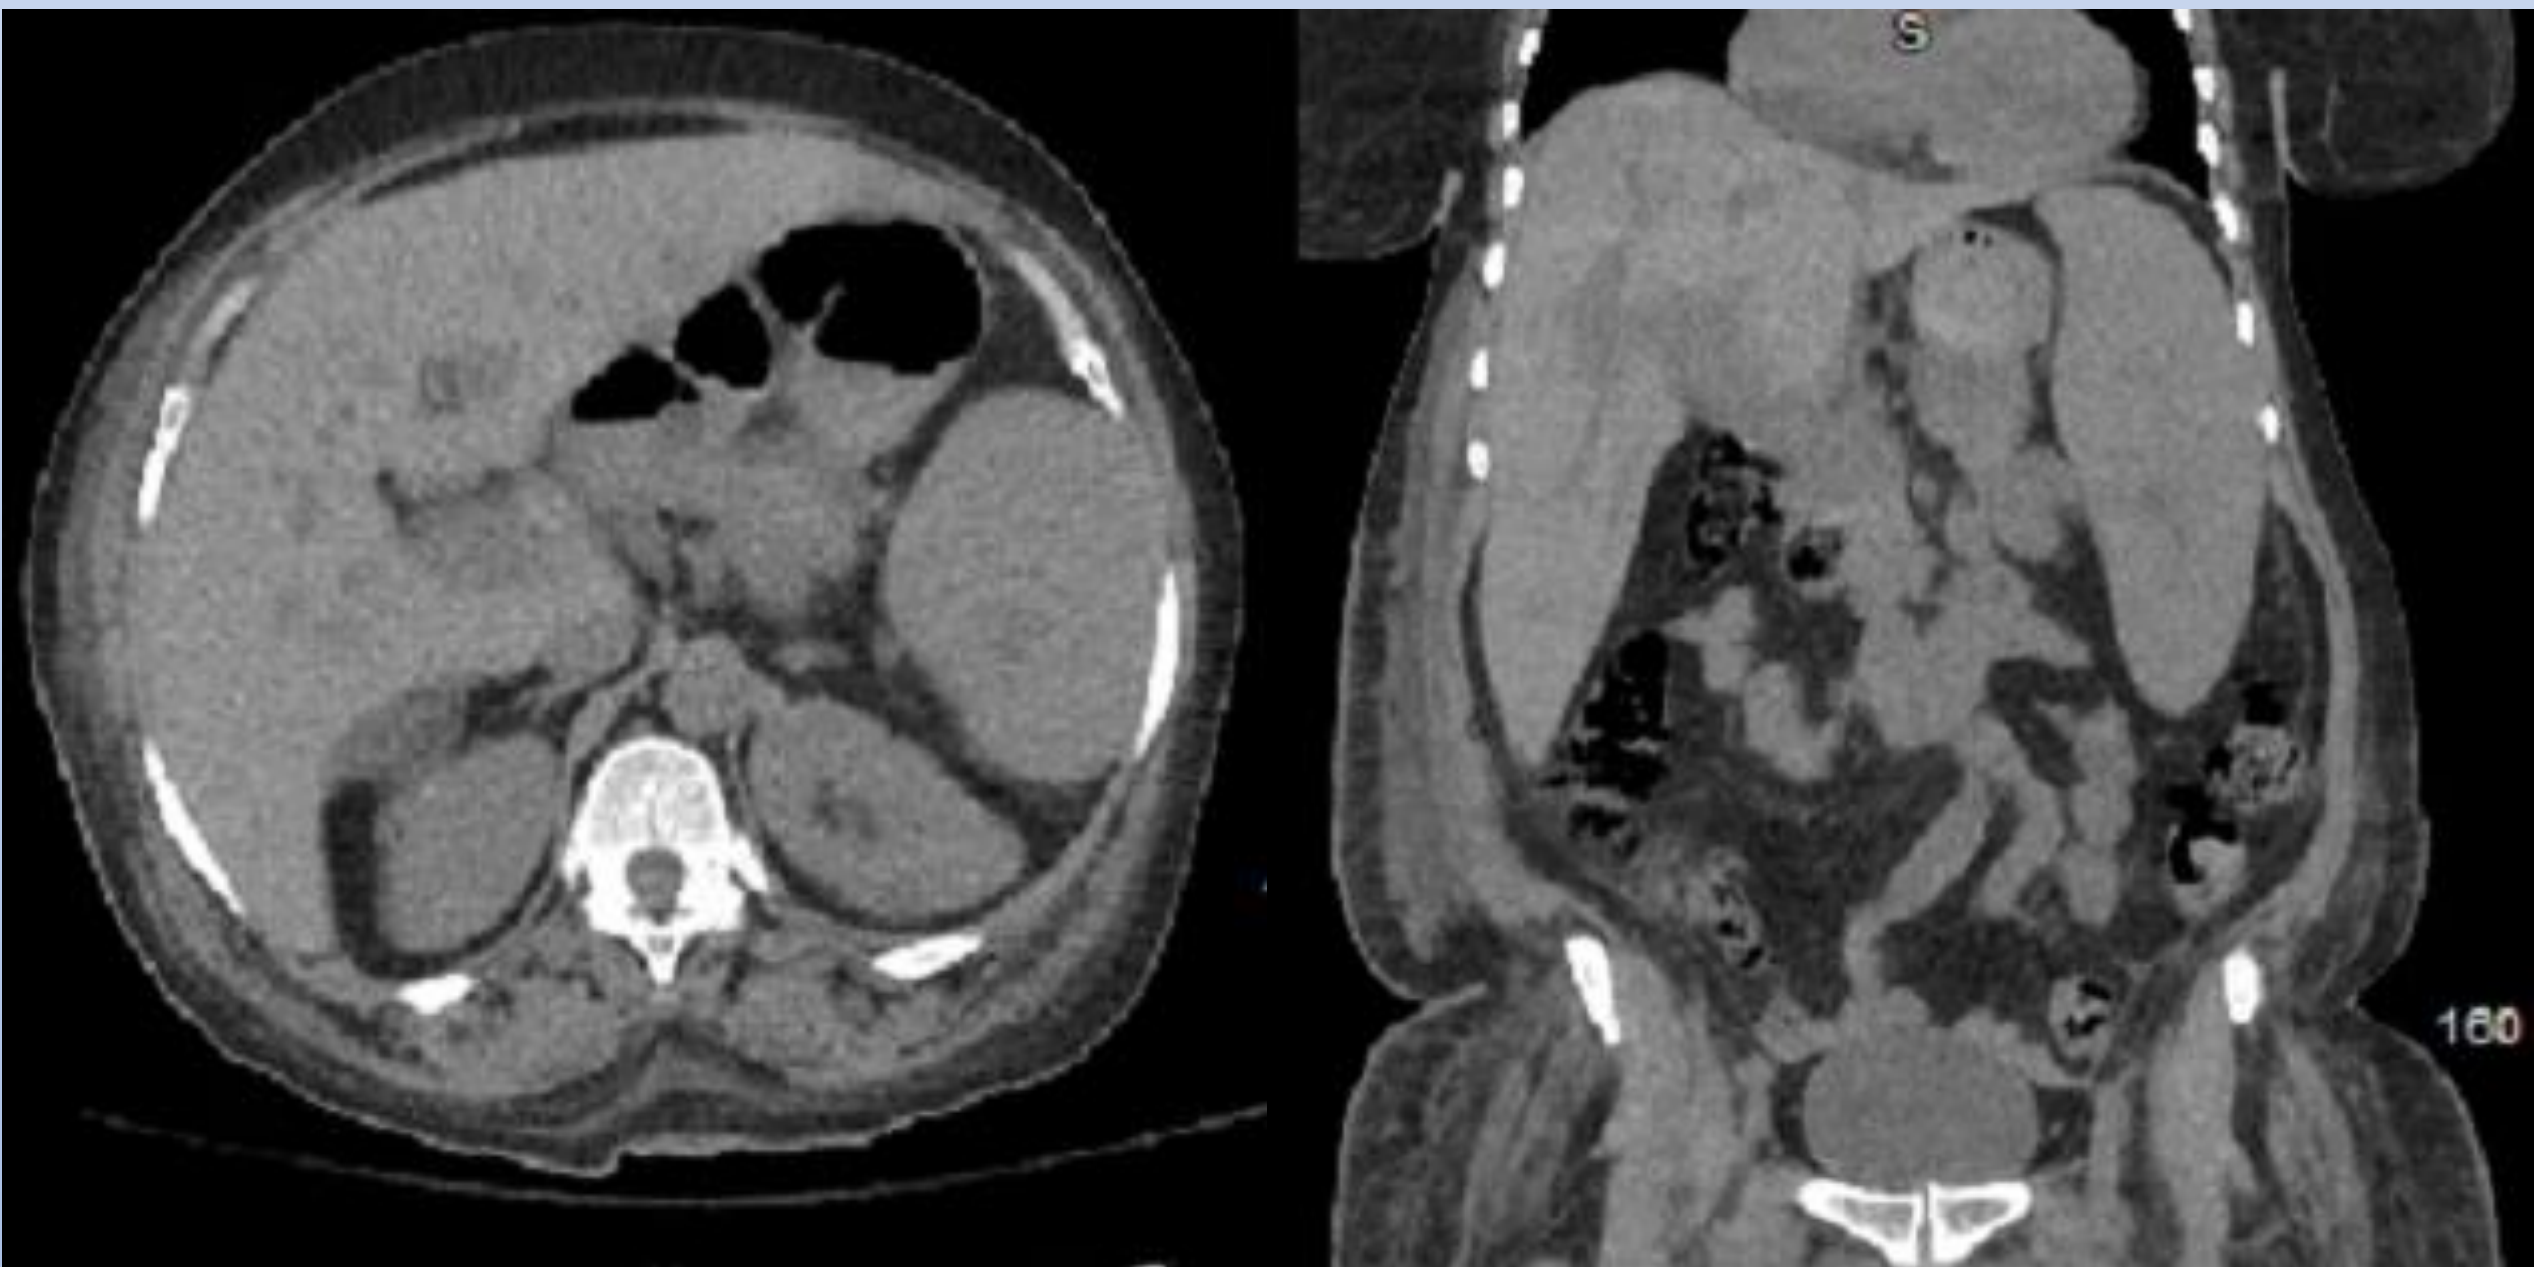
CT abdomen and pelvis without contrast showing splenomegaly with spleen measuring 21.1cm on hospital day 30 (a) axial view (b) coronal view
